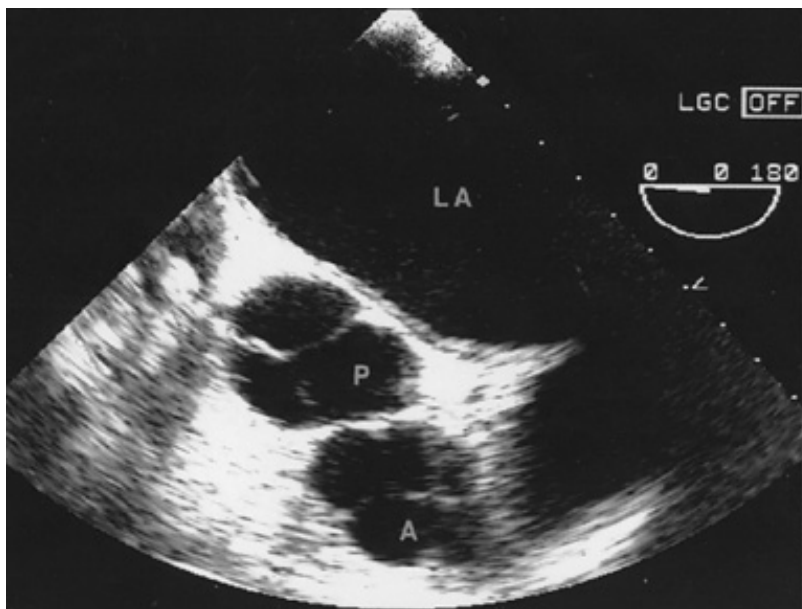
Transverse transesophageal image through the semilunar valves in L-transposition. The aortic valve (A) is anterior and to the left of the pulmonic valve (P). LA = left atrium.
